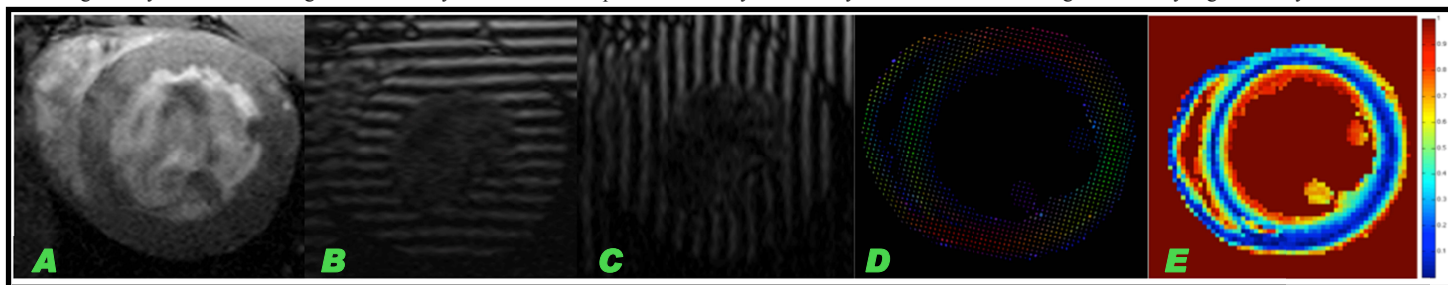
Short axis-view of a mid-ventricular slice: A) Cine MRI. B) Horizontal tagged image. C) Vertical tagged image. D) DTI. E) Fibers helix angle.
